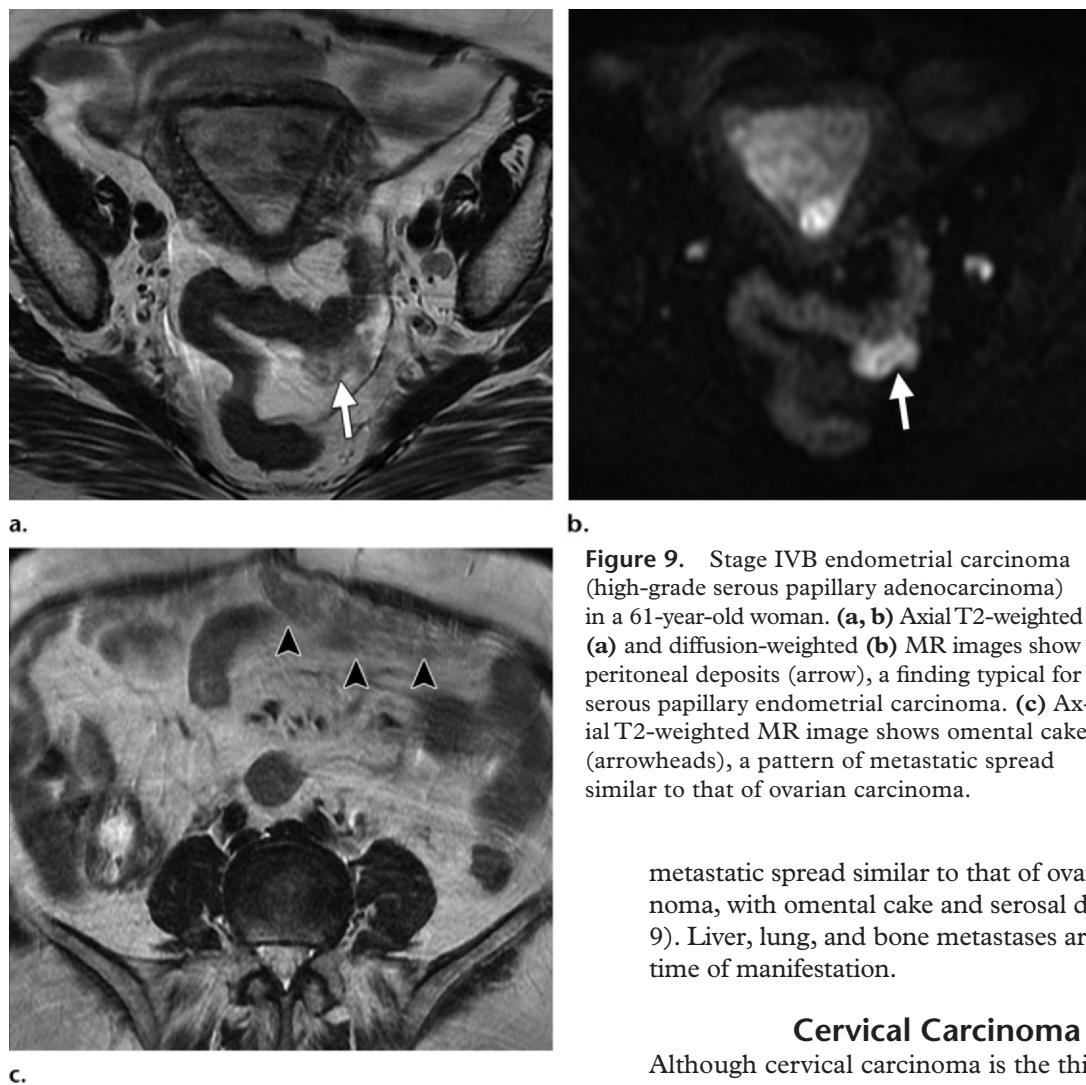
Stage IVB endometrial carcinoma (high-grade serous papillary adenocarcinoma) in a 61-year-old woman. (a, b) Axial T2-weighted (a) and diffusion-weighted (b) MR images show peritoneal deposits (arrow), a finding typical for serous papillary endometrial carcinoma. (c) Axial T2-weighted MR image shows omental cake (arrowheads), a pattern of metastatic spread similar to that of ovarian carcinoma.
